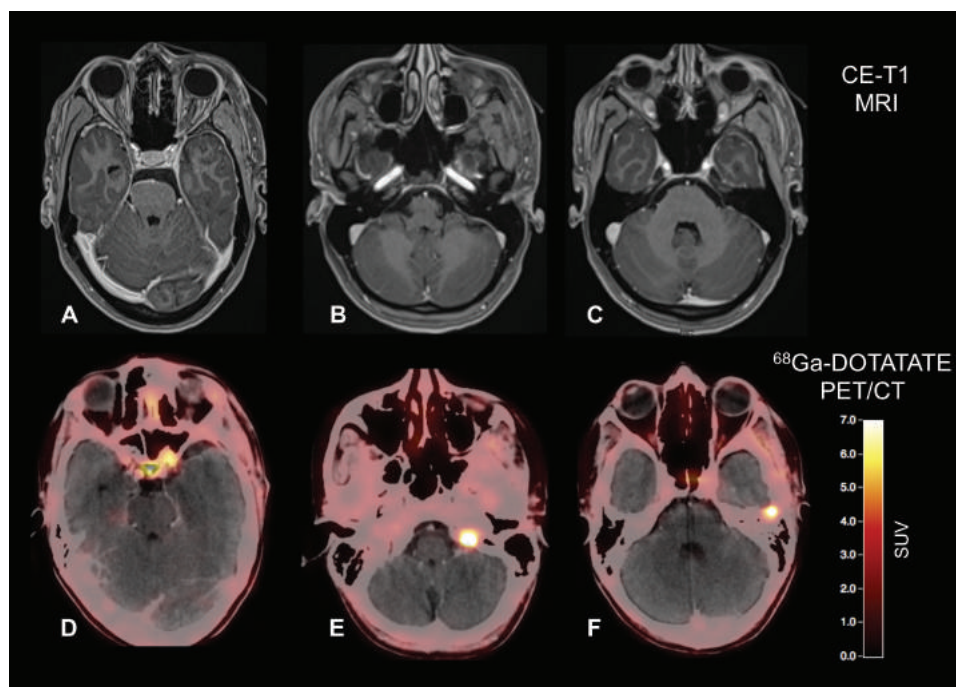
Postoperative contrast-enhanced MRI and ^{68}Ga -DOTATATE PET/CT of a 32-year-old patient after resection of a WHO grade I meningioma show residual tumor located at the left internal carotid artery and at tumor at the tip of the left orbit (A, D). Surprisingly, 2 additional meningiomas were also visible on the ^{68}Ga -DOTATATE PET/CT (E, F), without corresponding contrast enhancement on MRI (B, C).
